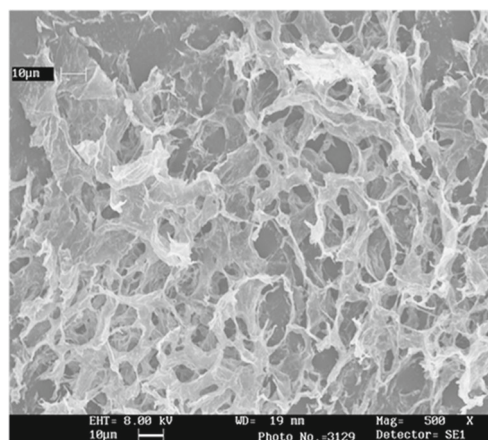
SEM image of the poloxamer gel corresponding to Fig. 2a. 1 Hz oscillatory frequency with simultaneous ultrasound application of 40 Hz and 75 W
